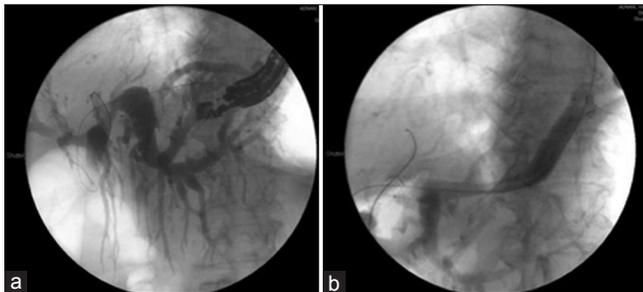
(a) An endoscopic ultrasound needle was inserted through the stomach wall and into the intrahepatic biliary ducts of the left lobe of the liver and after confirming correct position with injecting contrast a wire is introduced into the biliary system. (b) A specially designed partially covered metal stent is inserted so that one end is in the intrahepatic biliary system while the other end is in the proximal stomach
